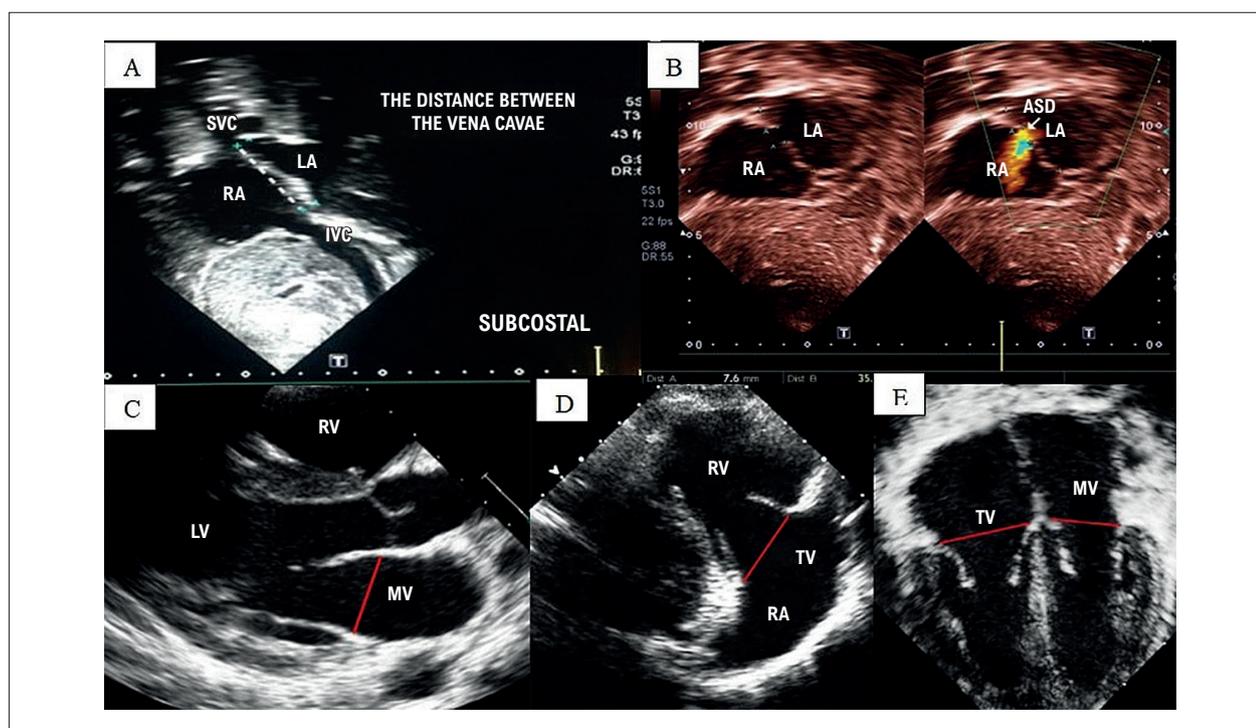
Measurement of the interatrial septum, ASD, and mitral and tricuspid annuli on echocardiographic examination. RA: right atrium; LA: left atrium; RV: right ventricle; LV: left ventricle; ASD: Atrial Septal Defect; IVN: inferior vena cava; SVC: superior vena cava; TV: tricuspid valve; MV: mitral valve.
